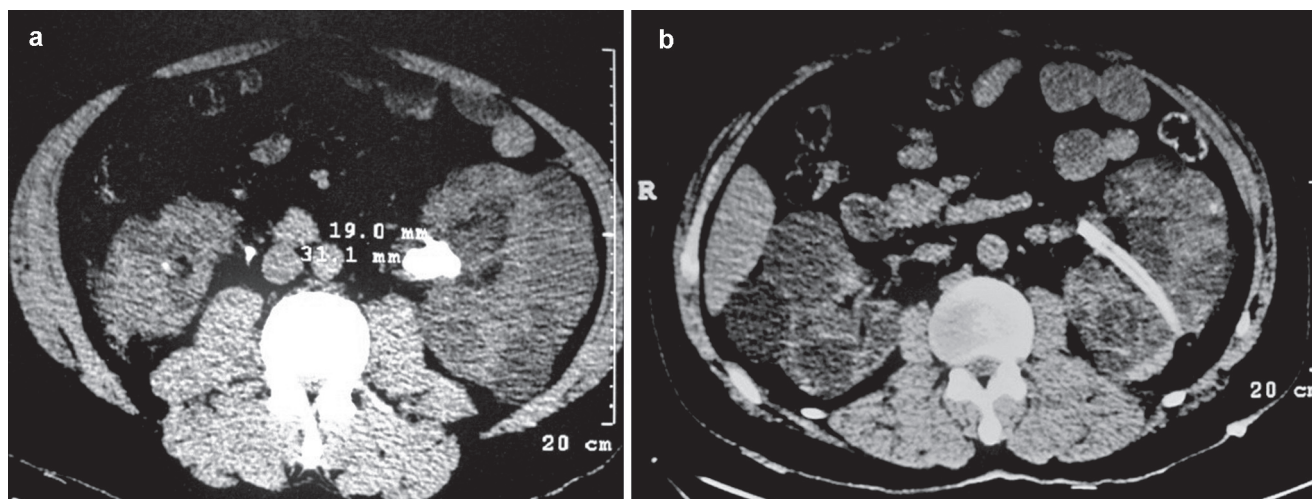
(a) Preoperative noncontrast computed tomography (NCCT), axial scan showing hyperdense stone in the renal pelvis of the left polycystic kidney. (b) Postoperative NCCT, axial scan showing left nephrostomy tube and no residual stones
